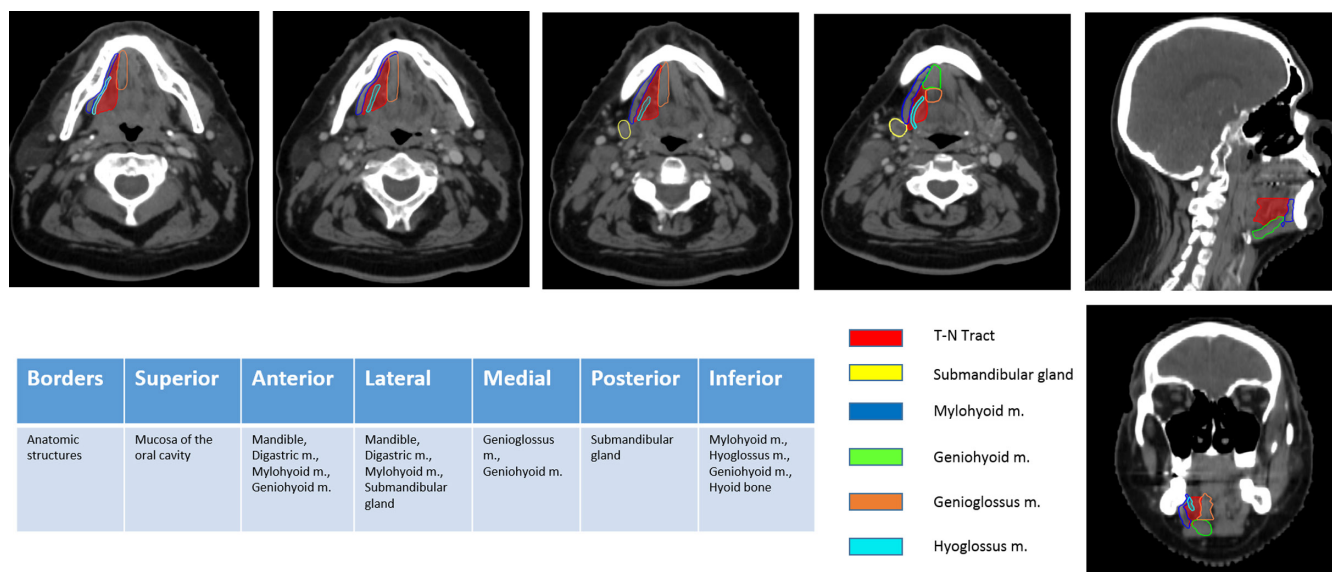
Anatomical boundaries of the T-N tract identified on computed tomography (CT) images
